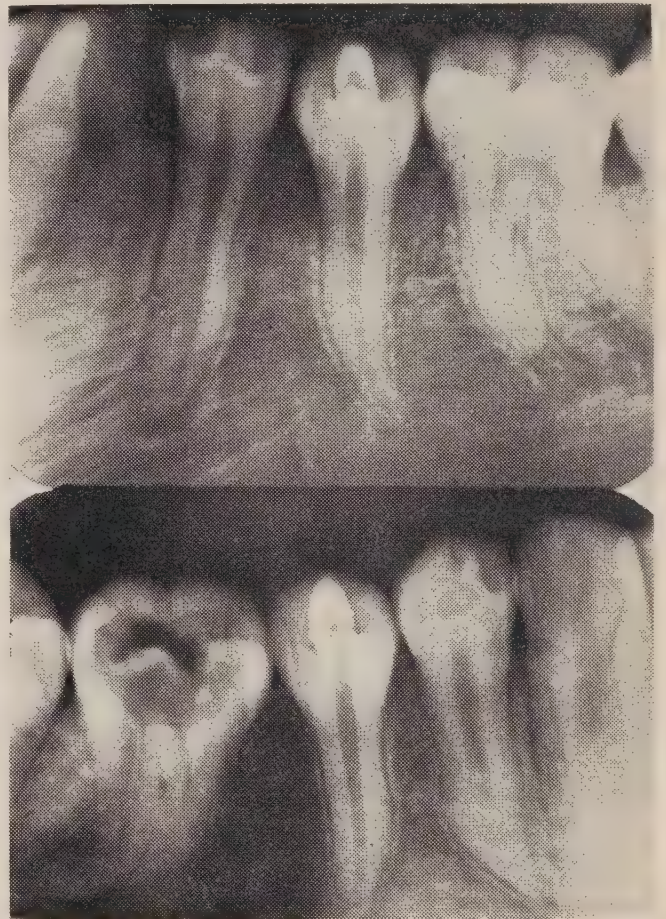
Radiographs of teeth in Figures 5 and 6. Upper radiograph is of the left side; lower radiograph, right side.
